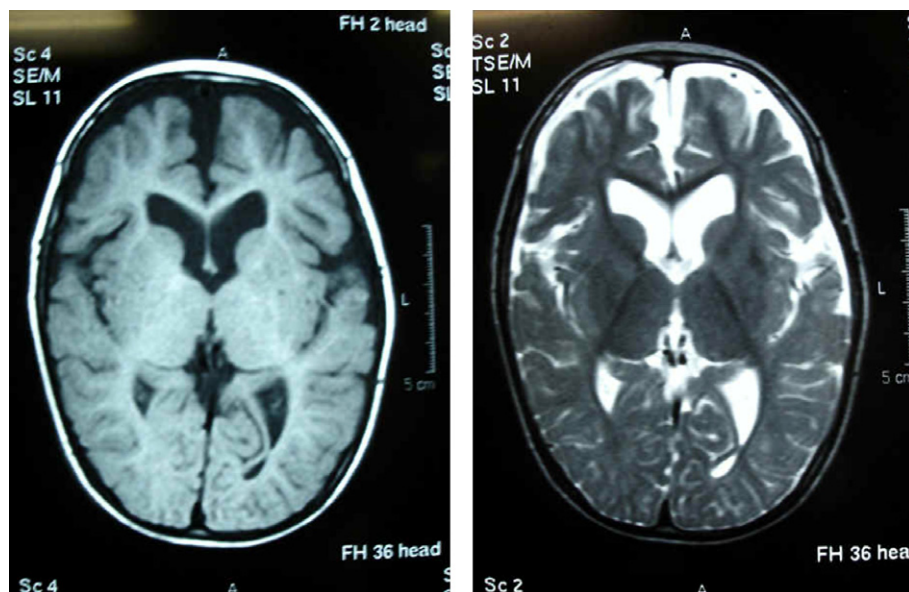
Cranial MRI at the age of one year showed the severe atrophic changes in white matter and the enlargement of ventricles.
